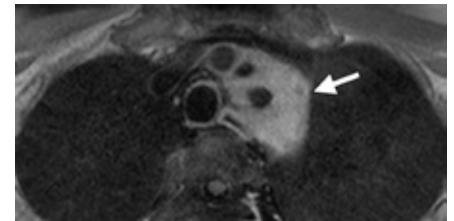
Biopsy-confirmed IgG4-related fibrosing mediastinitis: Contrast-enhanced T1-weighted MR image shows a homogeneously enhancing mass (arrow) encasing the branches of the aortic arch (brachiocephalic, left internal carotid and left subclavian arteries).
